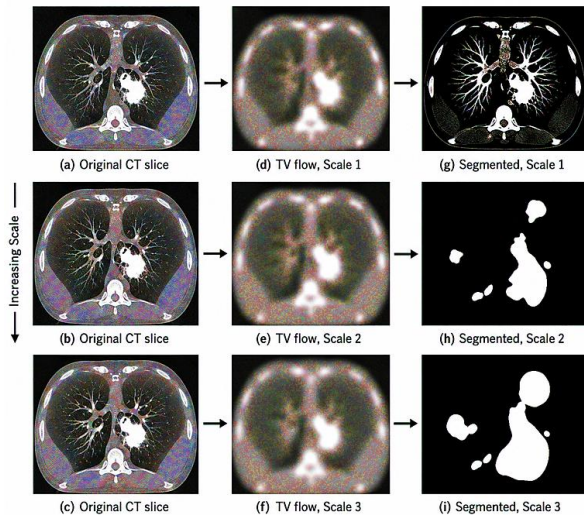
Scale-space stack and segmentation of a lung CT slice: (a) original CT slice, (b,d,f) TV flows at different scales, (c,e,g) segmented nodules and fibrosis.
